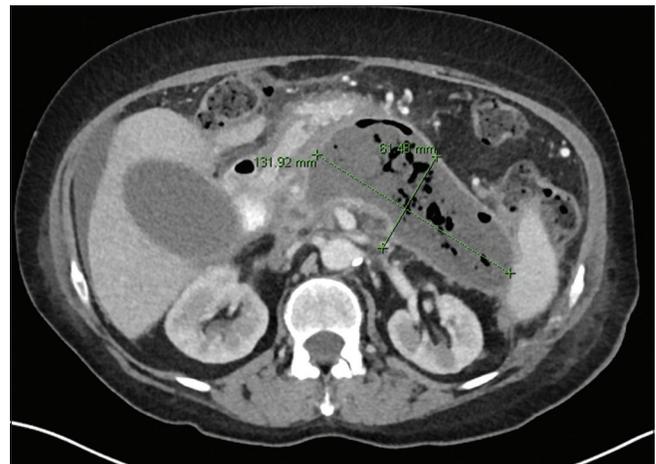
Abdomen computed tomography with a walled-off pancreatic necrotic collection measuring 132 x 61 mm.
